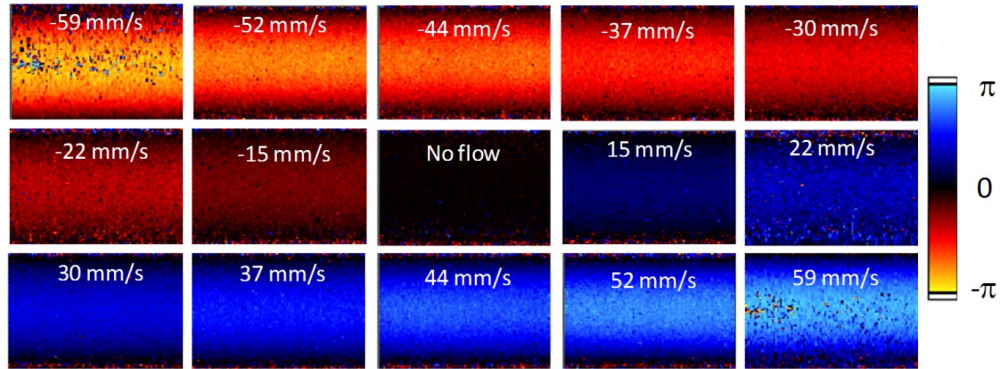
M-mode Doppler images calculated from the full-range signal at various flow velocities set by the pump
